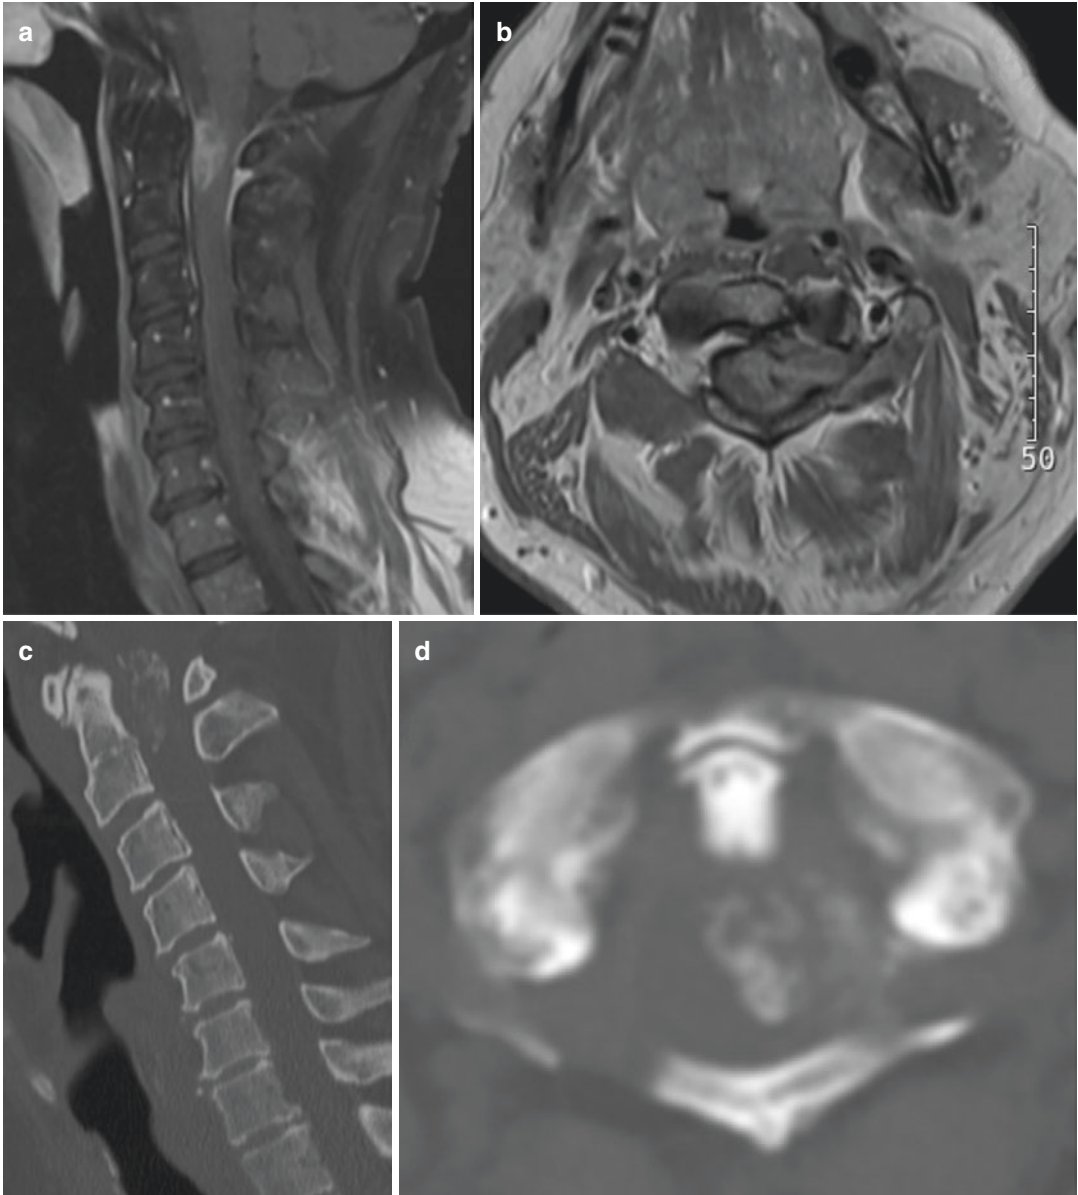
(a) Noncontrast sagittal (b) axial cervical spine demonstrating a partially calcified osseous centered behind the axis and eccentric to the left of the spinal canal. Postcontrast T1-weighted (c) sagittal (d) axial (e) MRI
